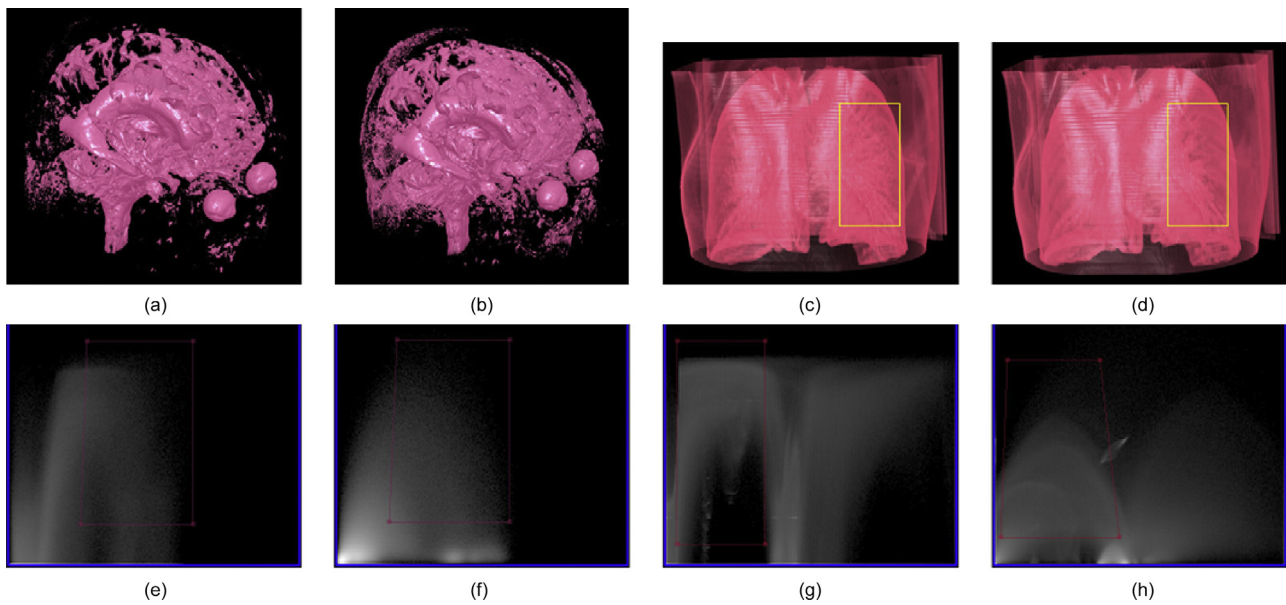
Two experiments for comparing the identify capability of the IS space and the IGM space on different tissue structures: a MRI ventricle (two left columns) and CT chest (two right columns). Boundary information of different materials are shown as ‘trapezoid’ shapes in the IS space ((e) and (g)), it is more intuitive to design transfer functions than the IGM space ((f) and (h)). Rendering images are shown on top of their transfer function space. The proposed method (yellow window in (c)) obtains more bronchioles than the IGM space (yellow window in (d)). (For interpretation of the references to color in this figure legend, the reader is referred to the web version of the article.)
